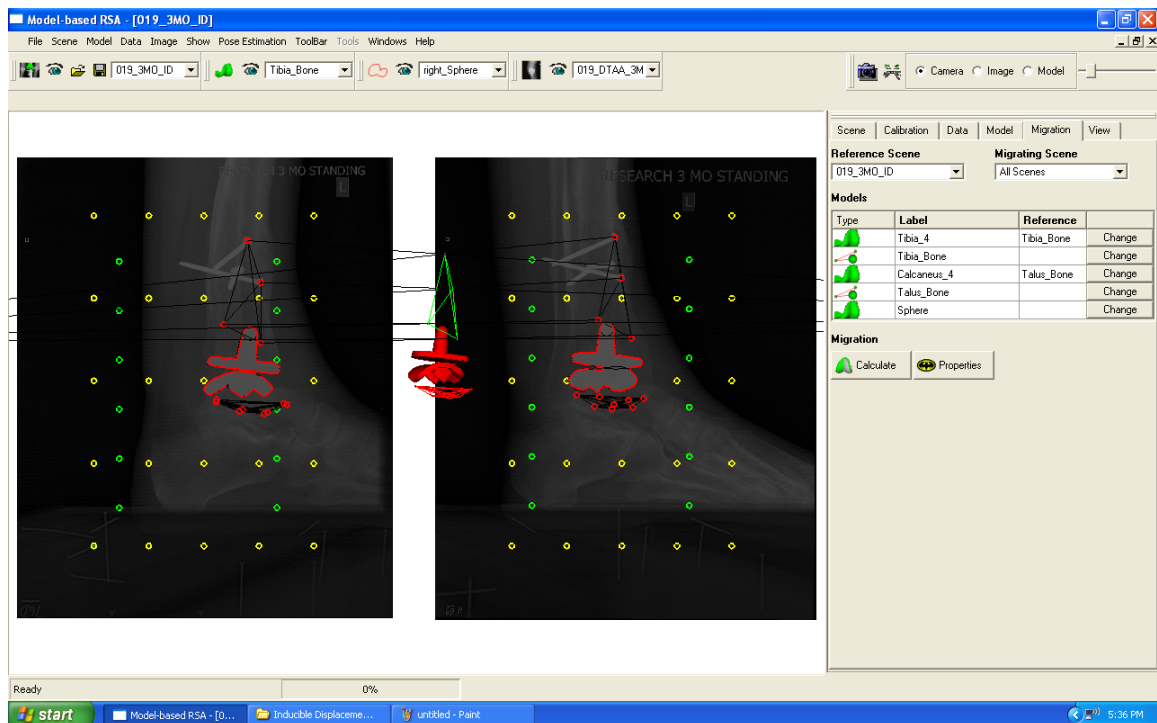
Model-based RSA 3.2 (Medis specials, Leiden, The Netherlands) screen shot showing the use of screw heads (upper two red circles in both radiographic views) to compensate for insufficient markers.
